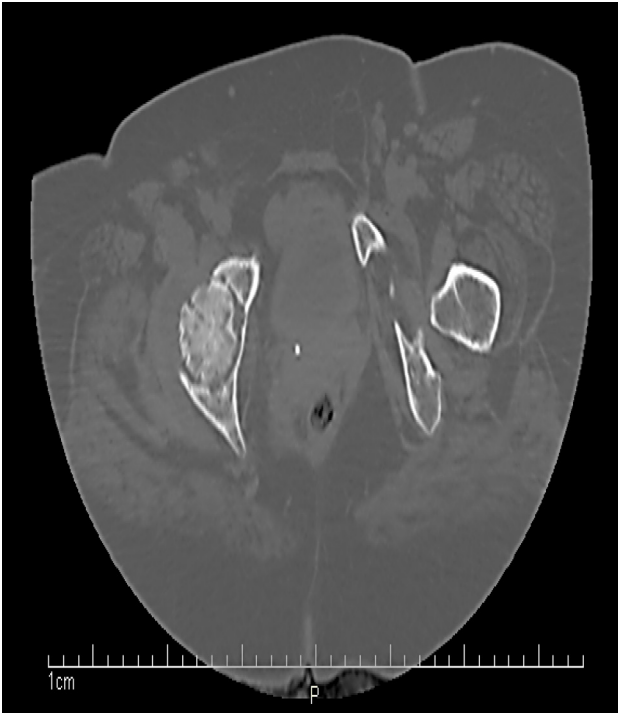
Axial CT scan of the pelvis without contrast: resorption of both femoral heads with advanced degenerative changes in the form of subchondral sclerosis and subchondral cyst formation in both acetabular and femoral head suggestive of advanced degenerative changes
